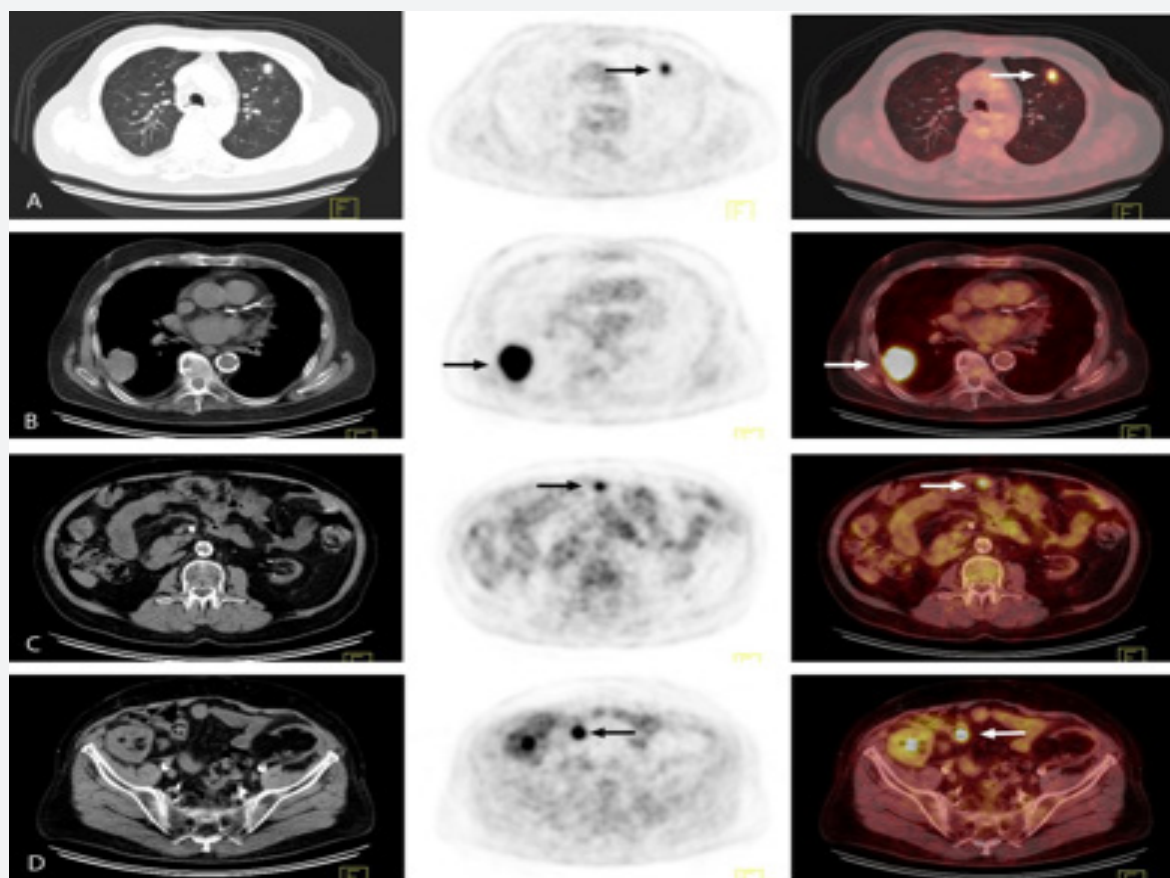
Simultaneous detection of squamous cell carcinoma of the lung and adenocarcinoma of colon in the same patient: Hypermetabolic lesions of the left lung (A), right lung (B), transverse colon (C), ileocecal region (D) and MIP* image (E) are shown on PET/CT images. MIP: Maximum Intensity Projection (whole body)
